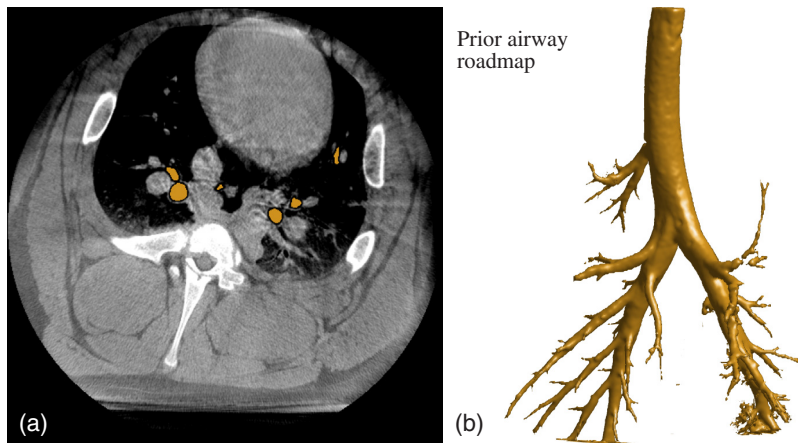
(a) Central CBCT slice with airway segmentation (beige). (b) Surface rendering of the segmented airway roadmap from prior CBCT.
